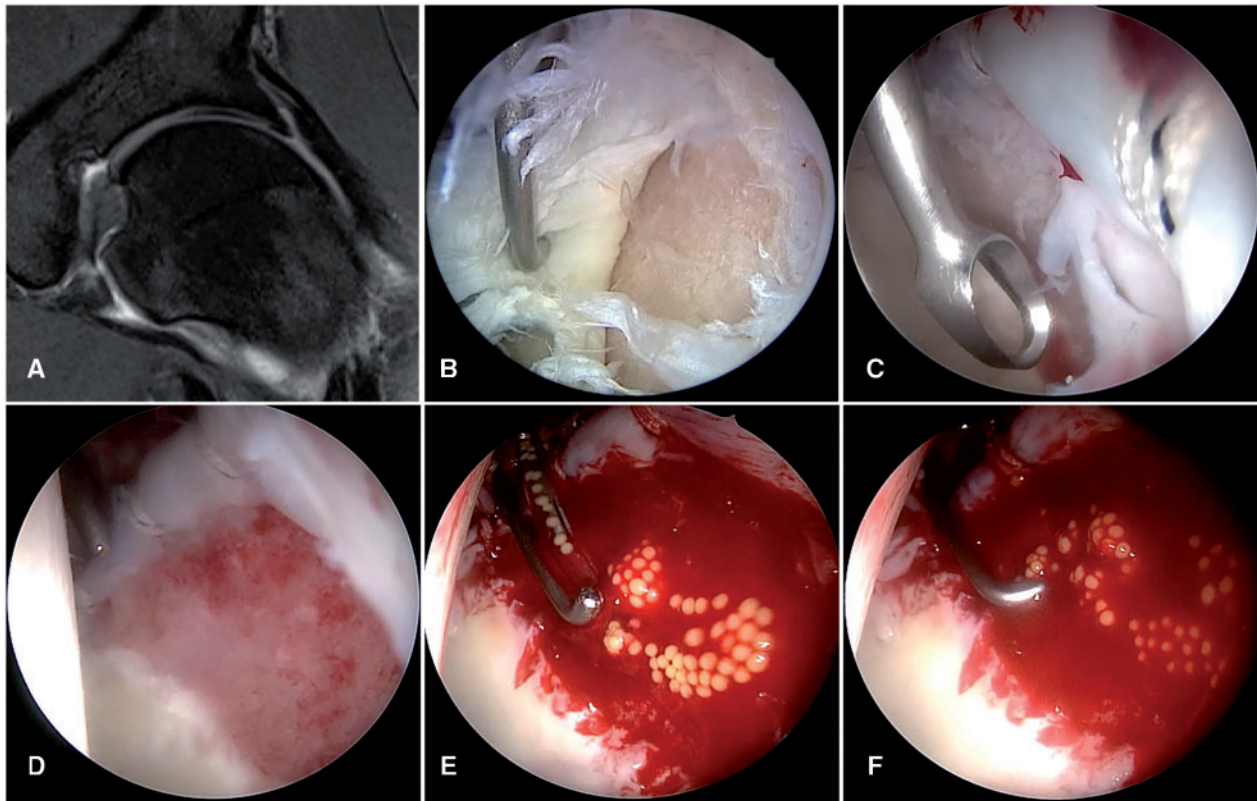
Arthroscopy of the central compartment of a left hip of a 26-year-old male patient. (A) MRI showing a large inverted ‘Oreo’ cookie sign [37]. (B) The diagnostic evaluation shows a large full-thickness acetabular cartilage flap with disruption of the chondrolabral transition zone. (C) The defect is debrided using a curette. (D) Contained cartilage defect after debridement of the unstable cartilage parts and refixation of the labrum. (E and F) Eight weeks after the initial hip arthroscopy the spheroids are inserted using the applicator.
